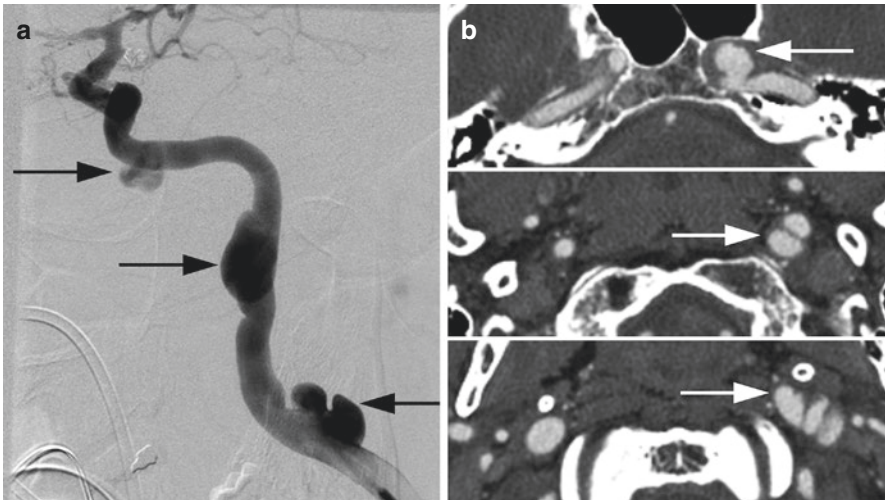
Petrous internal carotid artery pseudoaneurysm. Patient with fibromuscular dysplasia and a petrous ICA pseudoaneurysm. DSA (a) and CTA (b) demonstrate multifocal cervical ICA lumen corrugation (lower arrow), cervical ICA pseudoaneurysm (middle arrow), and petrous ICA pseudoaneurysm (lower arrow)
